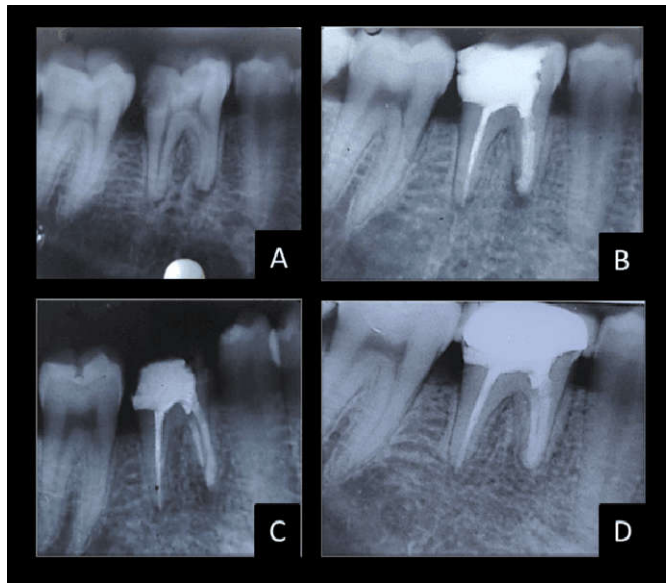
A)IOPA radiograph showed pulpal involvement with caries in #46 with periapical radiolucency involving the mesial root. B)After 1 month post-operative IOPA of #46. C)After 3 months post-operative IOPA of #46. D)After 6 months post-operative IOPA of #46.
